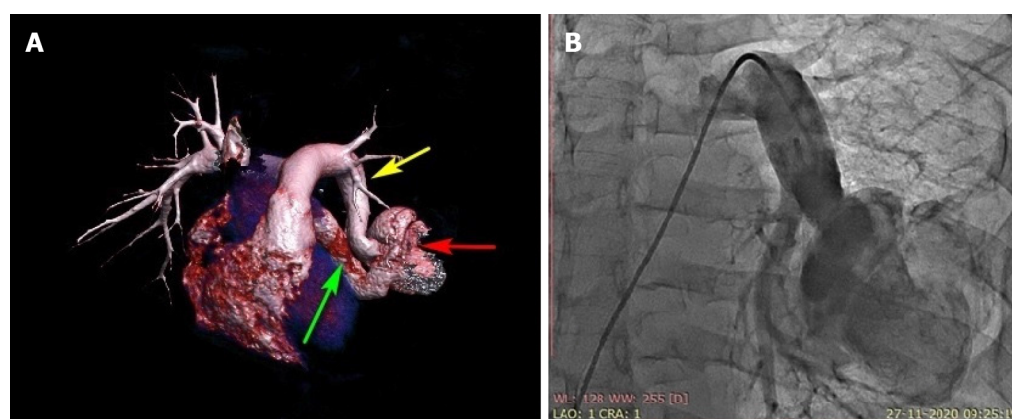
Three-dimensional computed tomography volume rendering and pulmonary artery angiogram. A: Contrast-enhanced computed tomography with three-dimensional reconstruction showing the left lower pulmonary artery-to-left atrial fistula with a highly tortuous course associated with an aneurysmal sac. Yellow arrow: left lower segmental artery; red arrow: aneurysmal sac; green arrow: last part of fistula connecting the left atrium; B: Anterior-posterior projection of pulmonary artery angiography using a 6-Fr pigtail catheter showing a highly tortuous large left pulmonary artery-to-left atrial fistula associated with a 6-cm aneurysmal sac. The right ventricular oxygen saturation was 79%, and the left ventricular saturation was 92% in room air without anesthesia.
